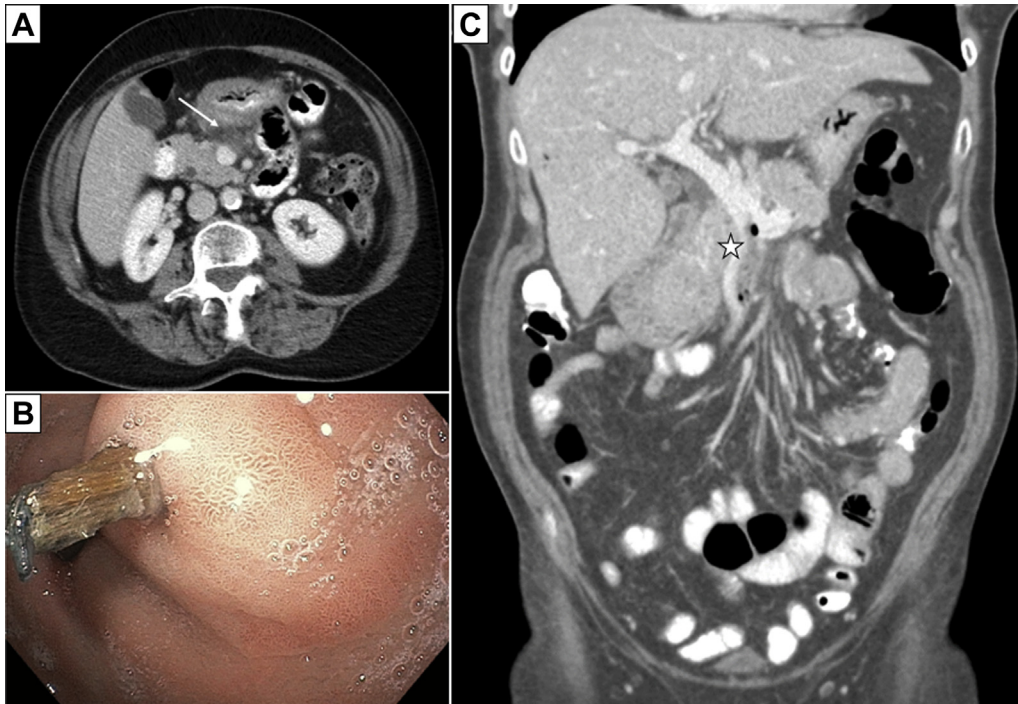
A, Initial computed tomography (CT) scan. Contrast-enhanced axial image shows thickened gastric antrum with surrounding inflammation (*arrow*). B, Endoscopic view of toothpick perforating the stomach. C, Follow-up CT scan. Contrast-enhanced coronal image shows superior mesenteric vein (SMV) thrombus and intravascular air (*star*).
